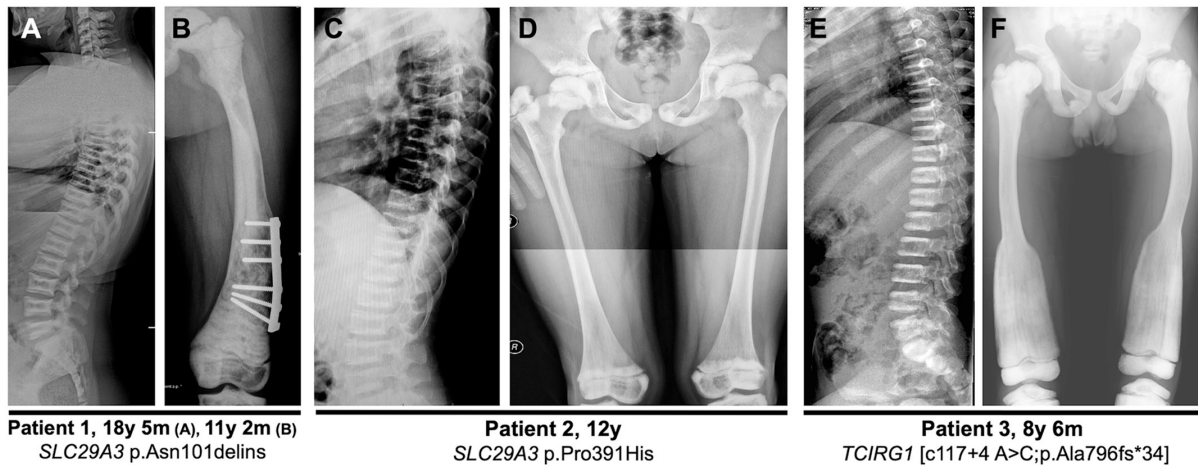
Radiographs of spine and lower extremities. Patient 1 (A, B) presents with diffuse osteosclerosis, reduced translucency in the long bones and pathologic fractures (osteosynthesis material present). The shape of the femur is altered, it appears to be shortened and broadened. The vertebral endplates are dense and the vertebrae flattened. Patient 2 (C, D) reveals sclerosis of the proximal femur, the pelvis and vertebrae, which are mildly flattened. Patient 3 (E, F) presents with bilateral sclerosis of long bones in lower limbs, a modeling defect, Erlenmeyer flask shaped deformity of the tibia, metaphyseal flaring of tibia and femur, and flattened sandwich vertebrae.
